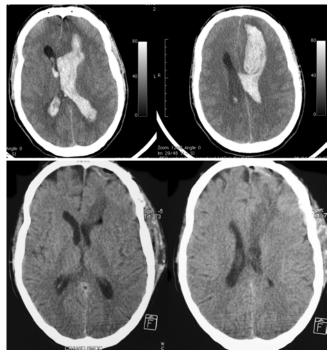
Upper: Computed tomography scans obtained with the telemedicine system, showing ICH and IVH in a 24-year-old patient. Cases of large lobar hemorrhage in young patients were centralized to undergo emergency CTA and surgical treatment. Lower: Computed tomography scans obtained after emergency surgical treatment.
